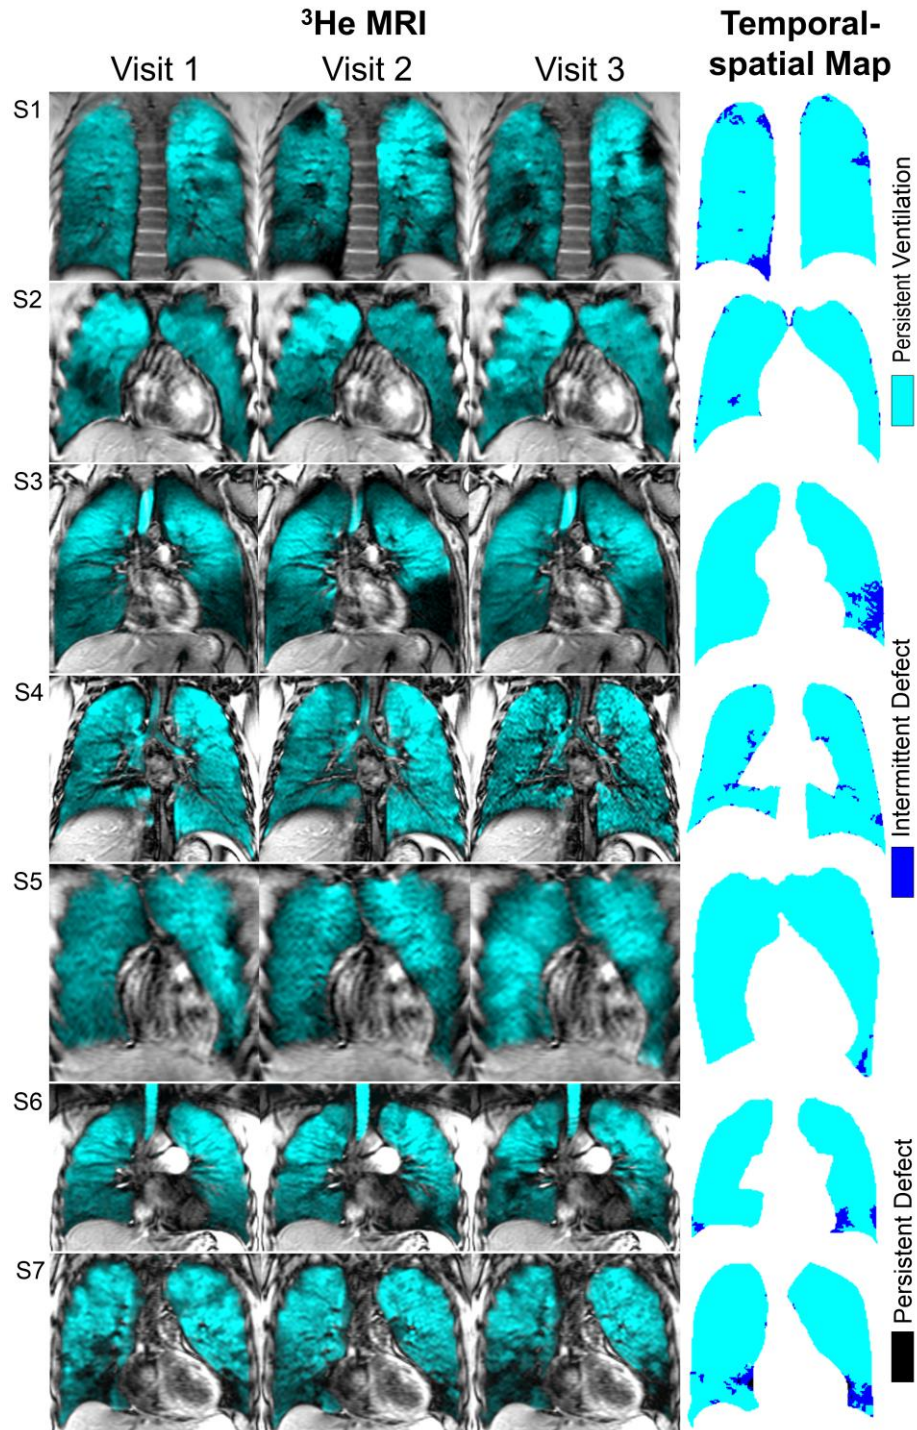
^3He MRI co-registered to the corresponding ^1H MRI acquired at visit 1-3, and the corresponding temporal-spatial pulmonary function maps for seven asthmatic subjects. Regional differences in the spatial distribution of ^3He MRI ventilation defects are visually apparent between visits for each subject. This short-term temporal ^3He ventilation defect behaviour is shown in the corresponding two-dimensional temporal-spatial map for each subject.
